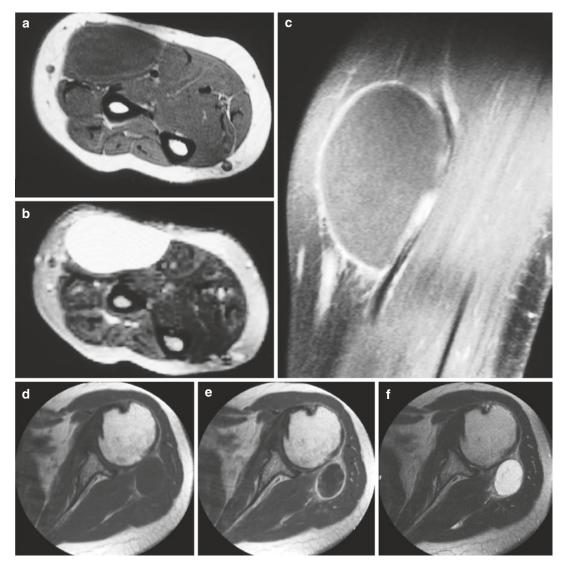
Two cases of fibromyxoid sarcoma (a–f). (a) Axial spin-echo T1-weighted MR image. (b) Axial spin-echo T2-weighted MR image. (c) Sagittal spin-echo T1-weighted MR image after gadolinium contrast injection with fat suppression. (d) Axial spin-echo T1-weighted MR image. (e) Axial spin-echo T1-weighted MR image after gadolinium contrast injection. (f) Axial spin-echo
